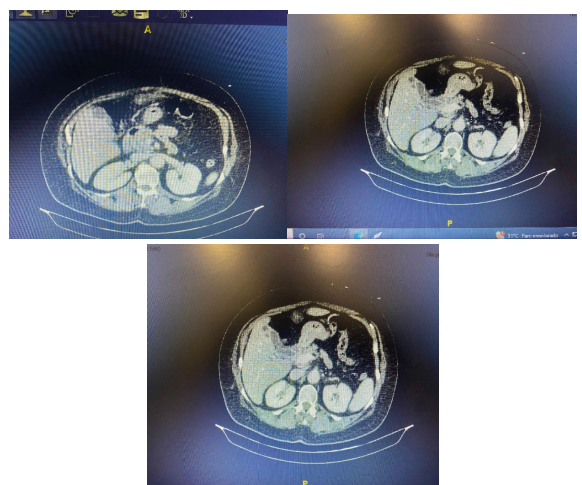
Computed tomography demonstrating thrombosis of the round ligament and infectious signs in the bile ducts
